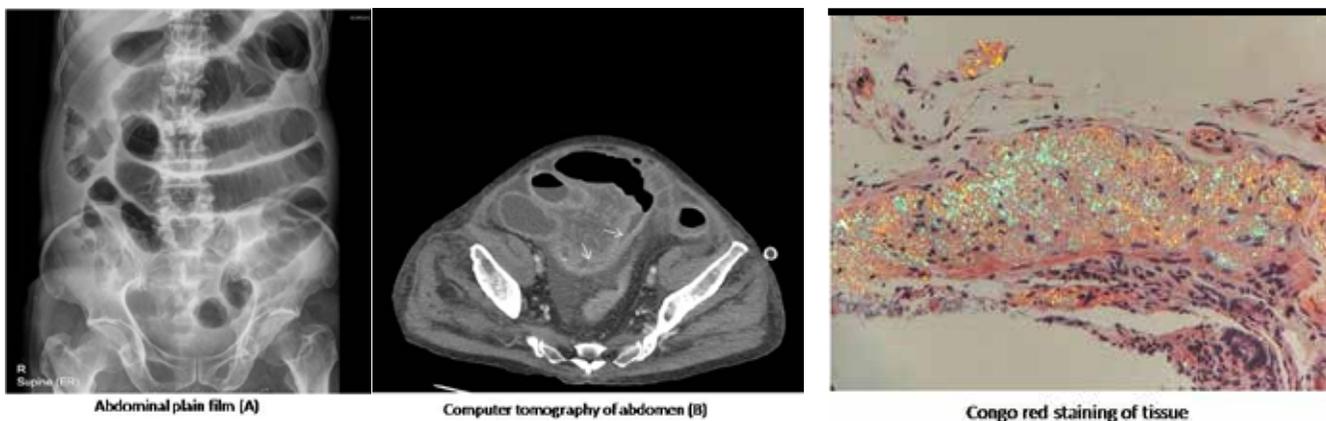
(Left) Plain abdominal film showed generalized marked disproportional dilatation of small bowel, without large bowel dilation. (Right) CT scan showed long segment abdominal wall thickening of ileum.
